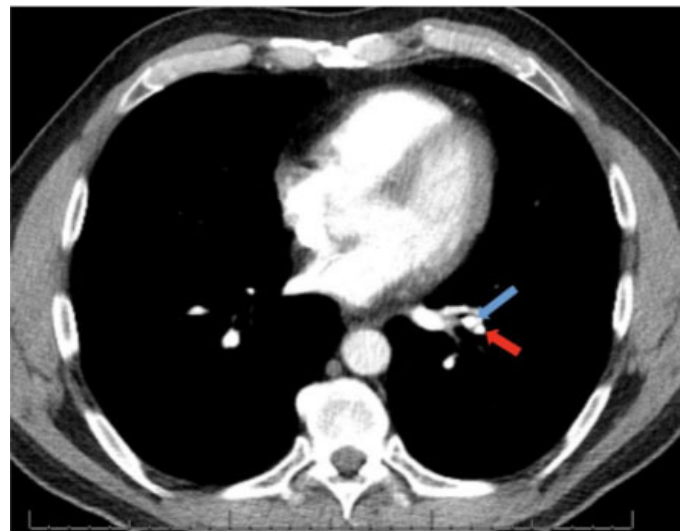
Axial CT-chest image demonstrating bronchololith in segmental branch of the left lower lobe (blue arrow) in close proximity to a segmental pulmonary artery (red arrow).
